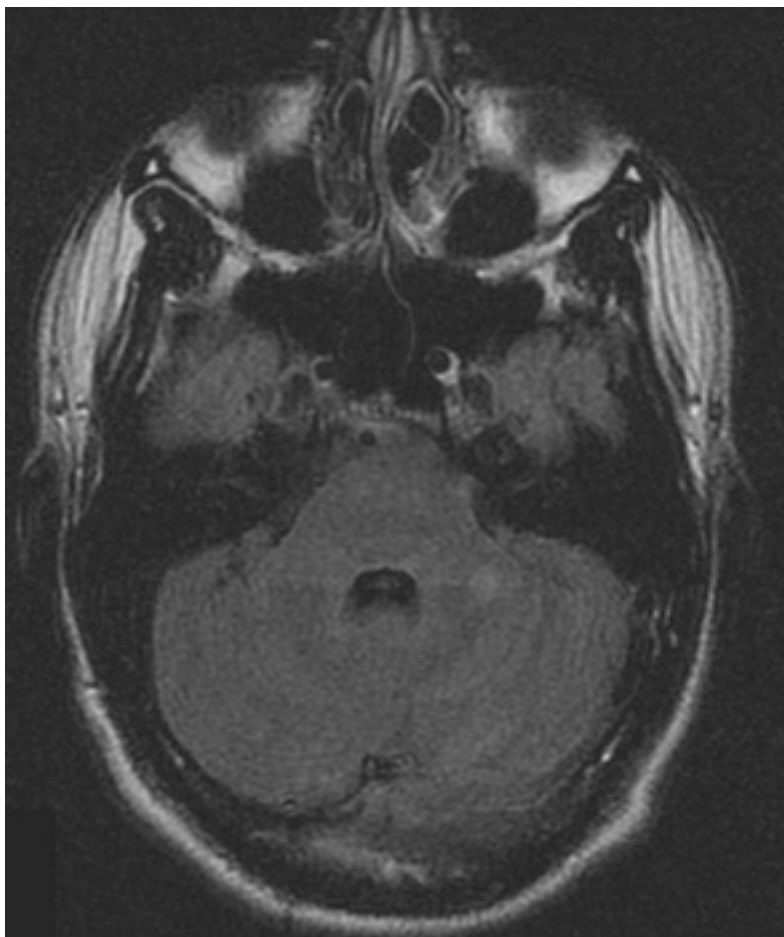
Series of MRI images of brain of patient with acute disseminated encephalomyelitis: hyperintense lesions of fluid attenuated inversion recovery (FLAIR) involving the left cerebellar peduncle
